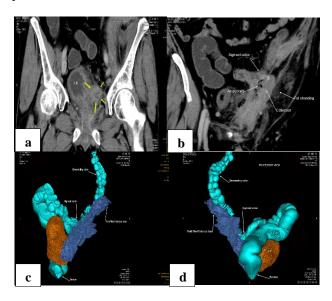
CT images including 3D reconstruction showing collection, which is abutting sigmoid colon and urinary bladder (a) yellow arrow showing collection abutting the urinary bladder; (b) fluid filled collection on the lateral aspect of sigmoid colon; (c) and (d) three-dimension reconstruction images of the collection and its relation to colon and bladder.
